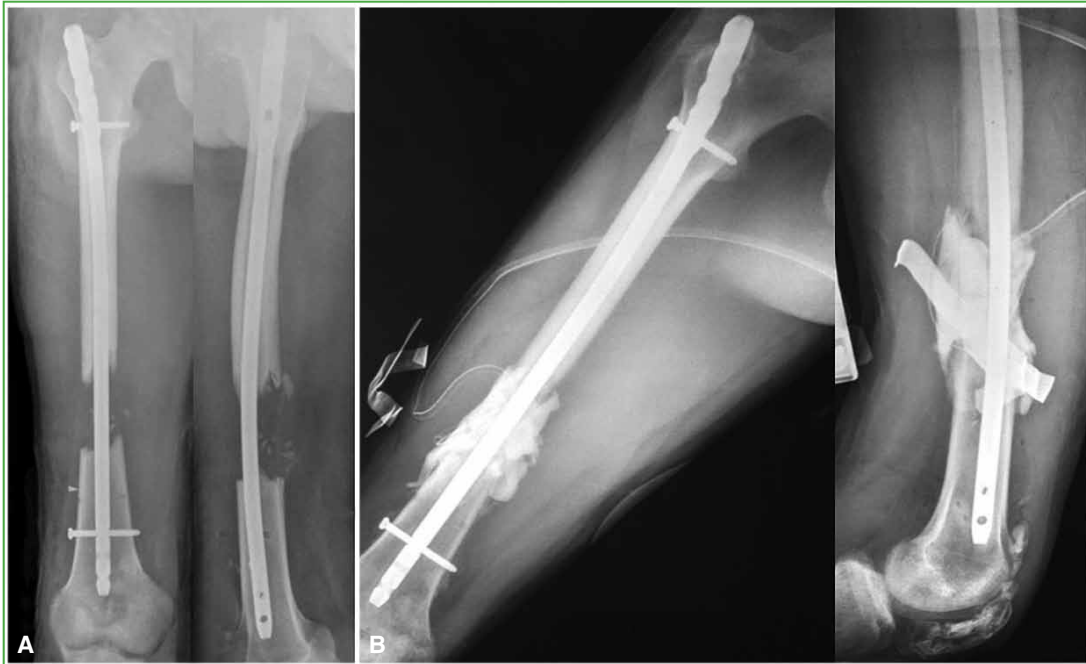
A. Postoperative radiograph of the entire right femur. Intramedullary nailing with length recovery without focus opening. B. Anteroposterior radiograph of the entire right femur after the second surgery to place a cement spacer for Masquelet membrane formation.
